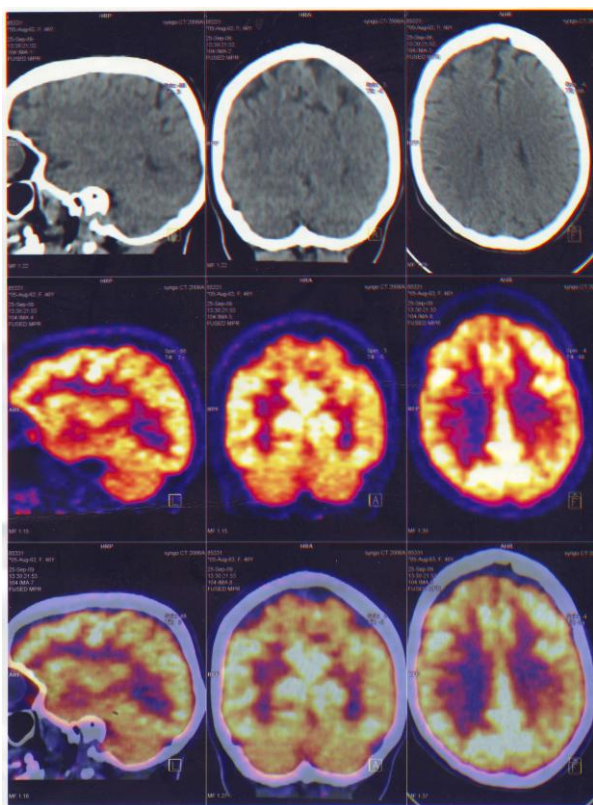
PET/CT finding.
